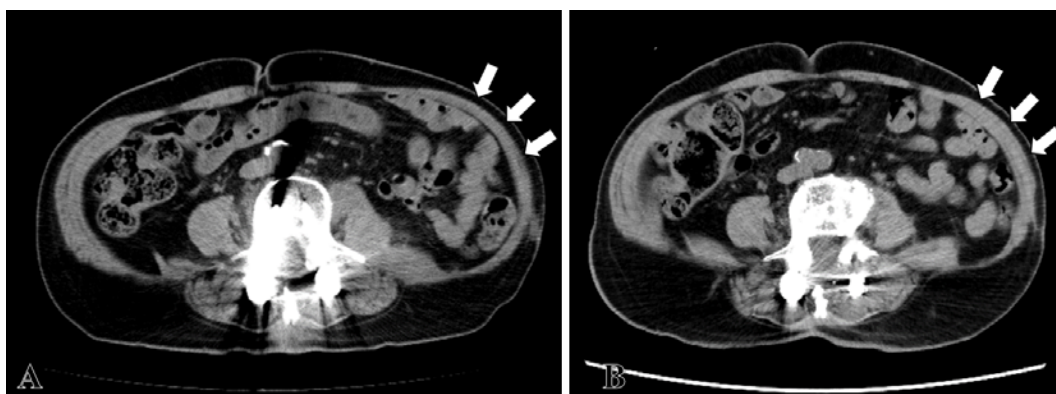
(A) An axial computed tomography image showing the thinned abdominal wall muscles at 3 months following surgery. There was no abdominal wall defect or hernia. There was abdominal wall bulging due to the abdominal contents. (B) An axial computed tomography image showing the symmetrical abdominal wall with recovery of the muscle thickness.
